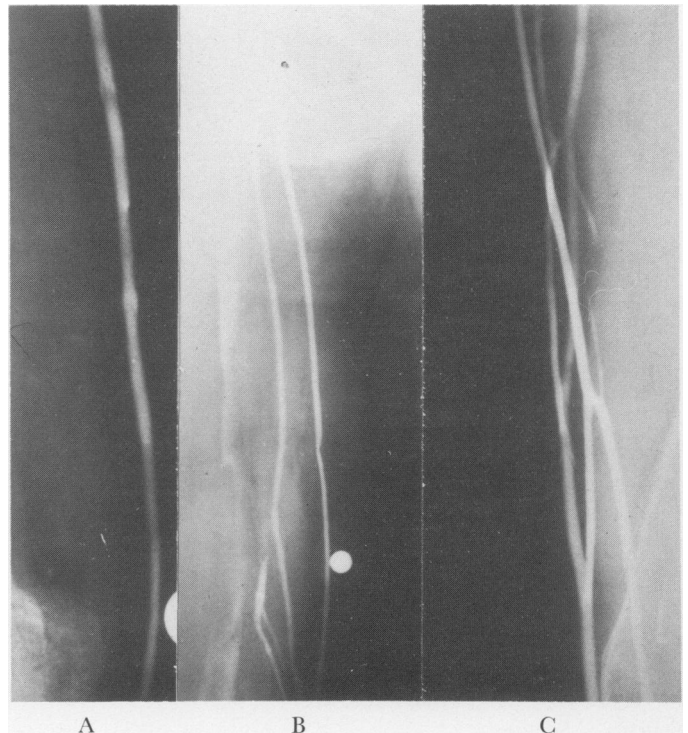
(A) A single long saphenous vein. (B) A phlebogram showing a double long saphenous vein which was successfully used for sapheno-femoral bypass. A ball bearing of known size has been placed along the course of the vein to allow correction for magnification. (C) A phlebogram showing a long saphenous network. A successful bypass was carried out using this vein. The X-rays are of different magnification.
